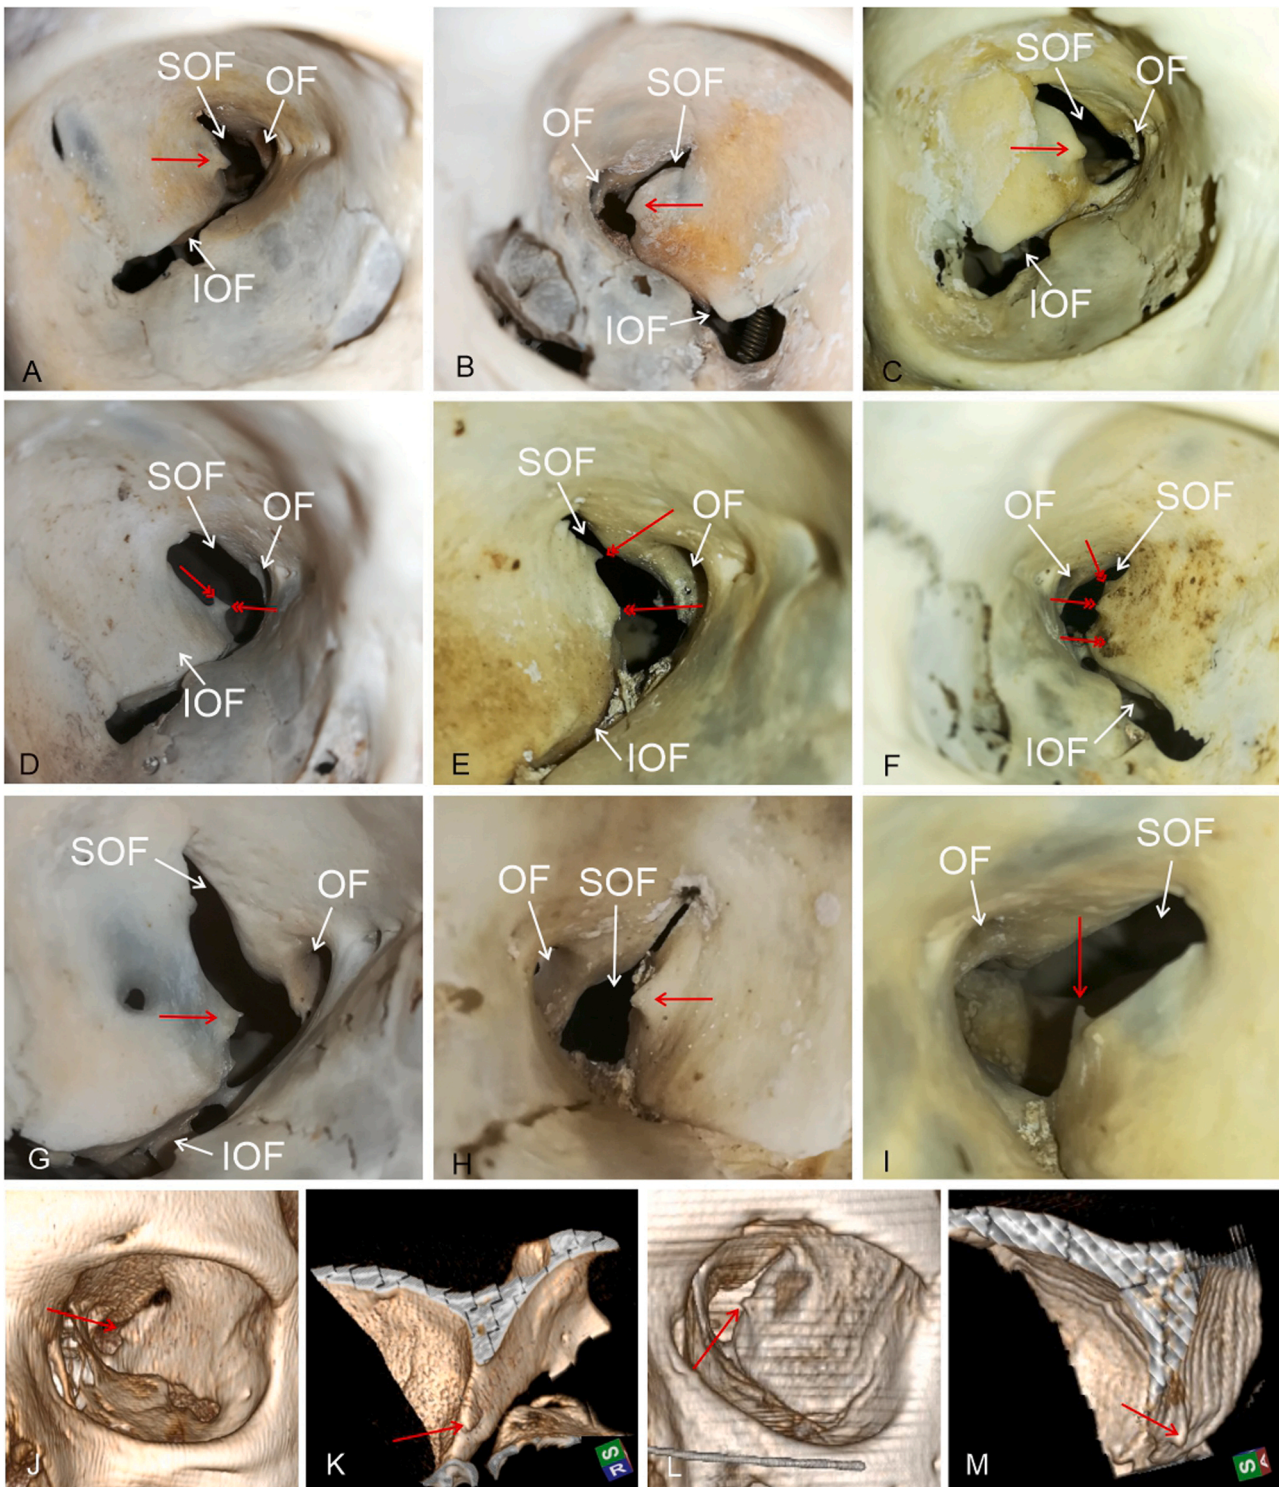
Morphologic variations of SMRLs (red arrows). OF = Optic foramen; SOF = superior orbital fissure; IOF = inferior orbital fissure. A) SMRL with a narrow base. B) SMRL with a wide base. C) SMRL with a smoothed point. D) Double SMRL (double-pointed red arrows) arising as a single process from the orbital plate of the sphenoid. E) Two independent spines (double-pointed red arrows) in the same orbit. F) Three SMRLs (double-pointed red arrows) simultaneously present in the same orbit. G) SMRL arising from the SOF margin; H) SMRL arising 3 mm in front of the SOF, plainly from the orbital plate of the sphenoid greater wing; I) A very peculiar SMRL points upward (-90° from the transverse plane). A second SMRL is also visible just in front of the highlighted spine; J) SMRL arising very close to the SOF margin as seen by 3D rendering of CT scans; K) The same SMRL in J as seen after clipping away most of the skull and leaving the orbital plate of the sphenoid and part of the sphenotemporal fossa. Oblique view from medially, above and behind. L) A 2.3 mm high SMRL arising 1.6 mm in front of the SOF margin as seen by 3D rendering of CT scans; M) The same SMRL in L as seen after clipping away most of the skull and leaving the orbital plate of the sphenoid and part of the sphenotemporal fossa. Oblique view from above, medially and behind.
